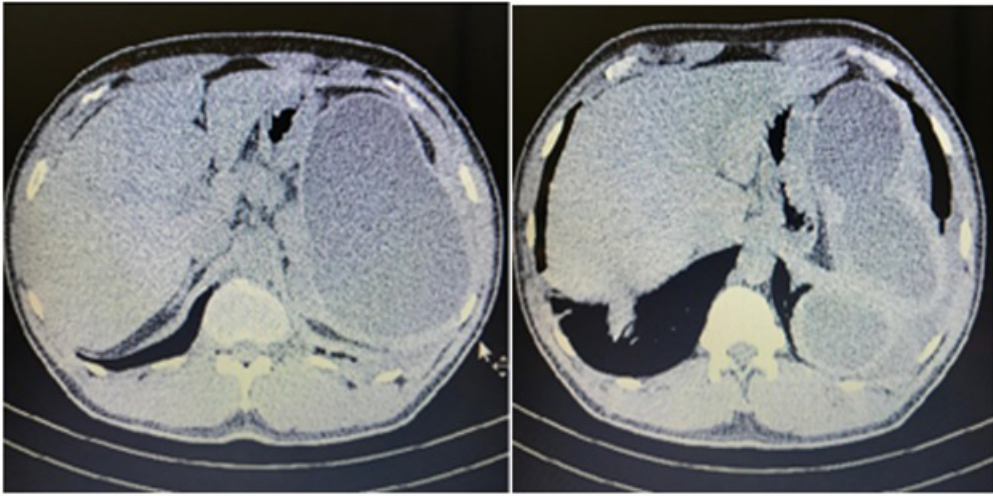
Show CT-sca of abdoman with cystic mass of spleen.
